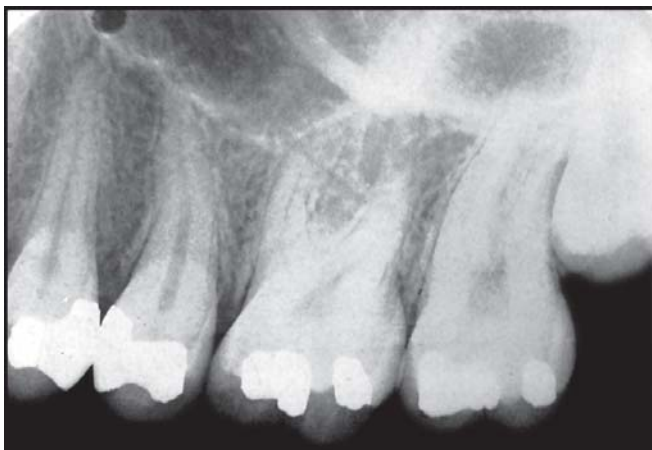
Manufacturers raised dot should be placed toward the incisal or occlusal surface of the teeth during exposure of a periapical film. The dot seen in the given radiograph is superimposed over the apical end of the maxillary first premolar
